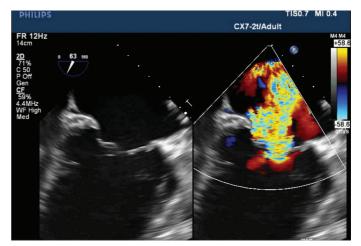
Transesophageal echocardiography demonstrates severe mitral regurgitation between A2–P2 scallops and mild-to-moderate regurgitation between A3–P3 scallops
